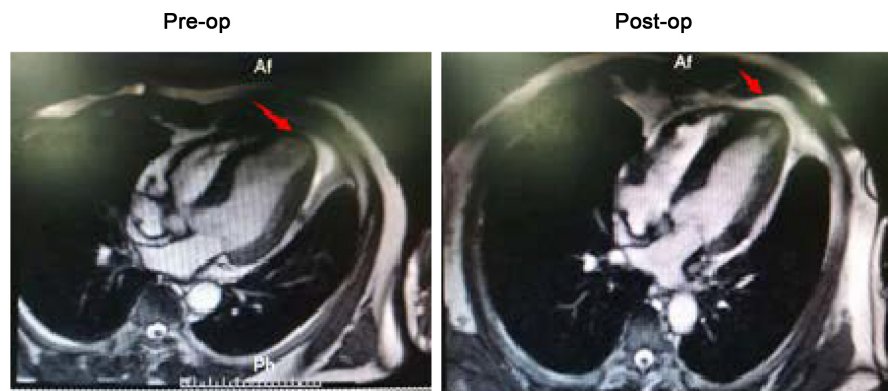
MRI indicated the increase in wall thickness after treatment (red arrows).
